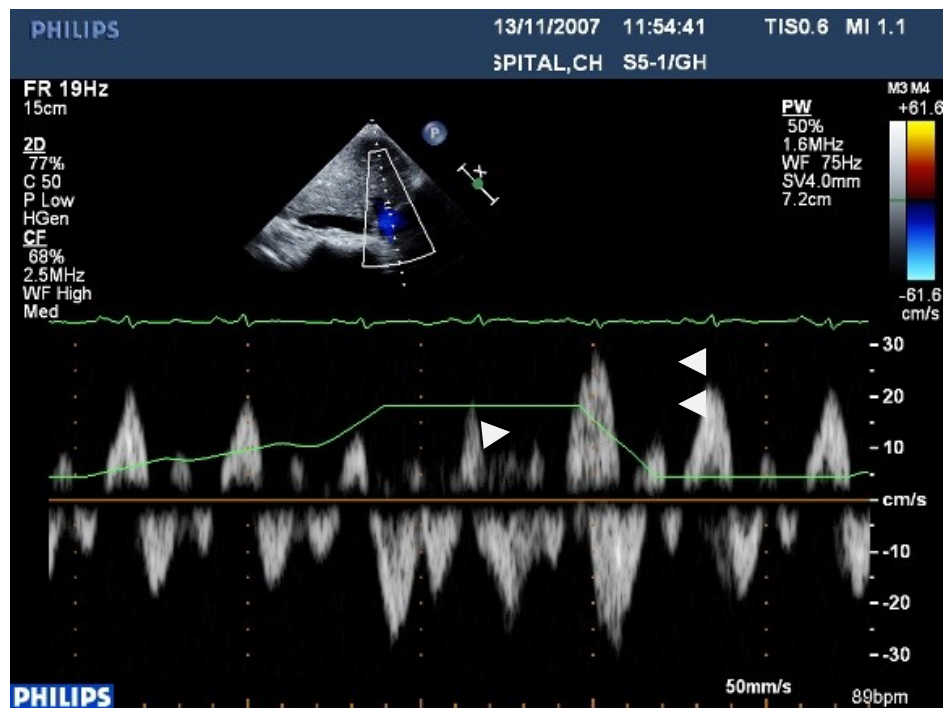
Hepatic Vein Doppler – exaggerated diastolic reversal (DR) during expiration (double arrow head)
